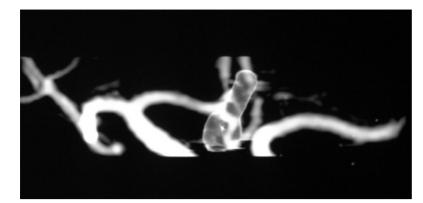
A 52-year-old man with postsurgical clipping of ruptured anterior communicating aneurysm. Volumerendered CTA image reveals the clip and the adjacent arterial structures. Residual lumen of the aneurysm is not depicted. Contrast angiography also shows no residual lumen of the aneurysm.
